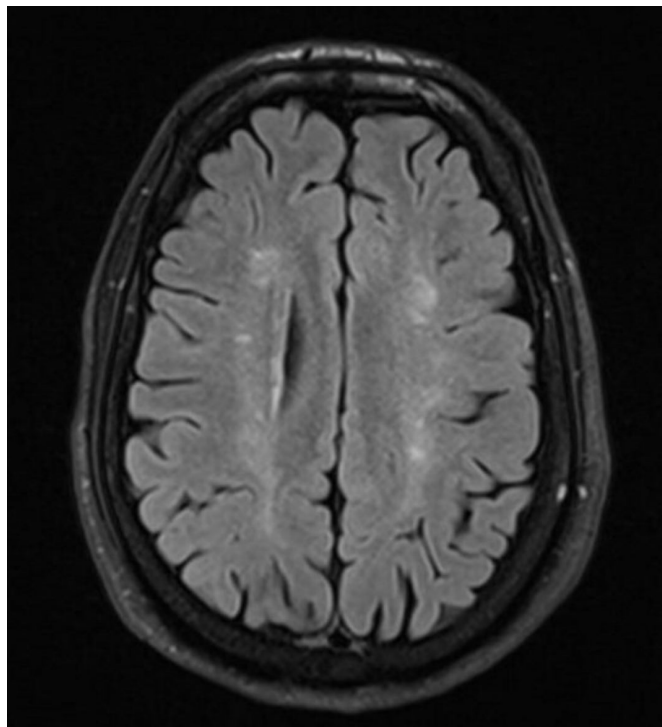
Brain MRI images showing T2-weighted-Fluid-Attenuated Inversion Recovery (FLAIR) hyperintense lesions without gadolinium enhancement on both *corona radiata*/semioval centres bilaterally.
